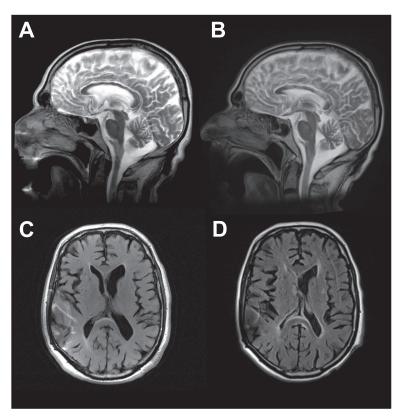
Baseline MRI (A, C: 1.5T-GE_Medical-System-Signa-Excite) and 3-weeks after anoxia (B, D: 1.5T-Siemens-Magnetom-Avanto). Baseline lacks alterations in the corpus callosum (A: T2-sagittal) and white matter (C: FLAIR/T2-axial). Anoxia produced T2 hyperintense lesions of corpus callosum appearing thickened, while rostrum and splenium are partly spared (B) as well as bihemispherical white matter (D).
